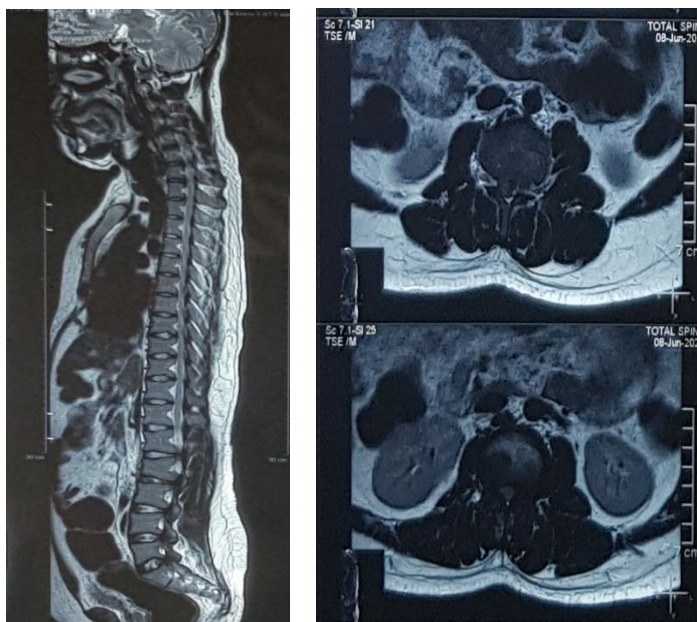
Whole Spine Sagittal View and Axial MRI showing stenosis in several level of lumbar spine and ossification of ligamentum flavum
